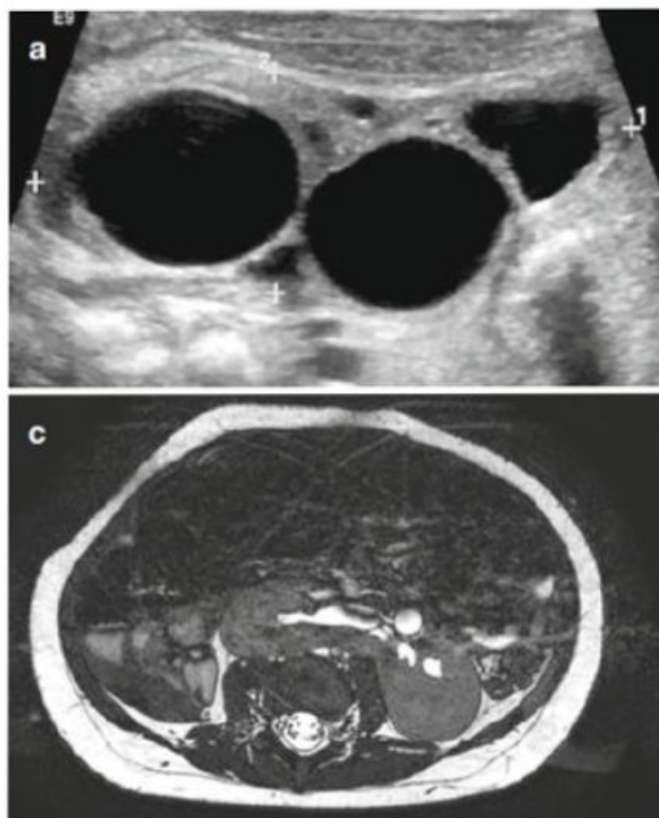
Absent kidney (multicystic, dysplastic). (a) Ultrasound showing an image of a multicystic kidney. (b) Renal scan showing an absent kidney. (c) MRI showing a horseshoe kidney
